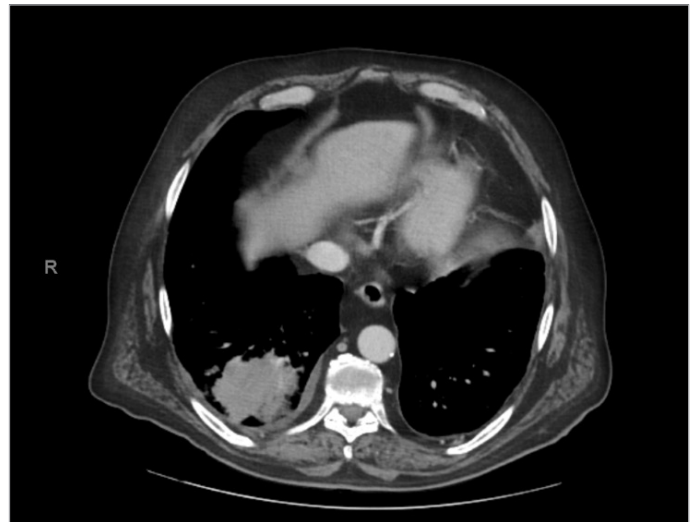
Body-CT scan. It showed image compatible with right lower lobar bronchogenic carcinoma.
